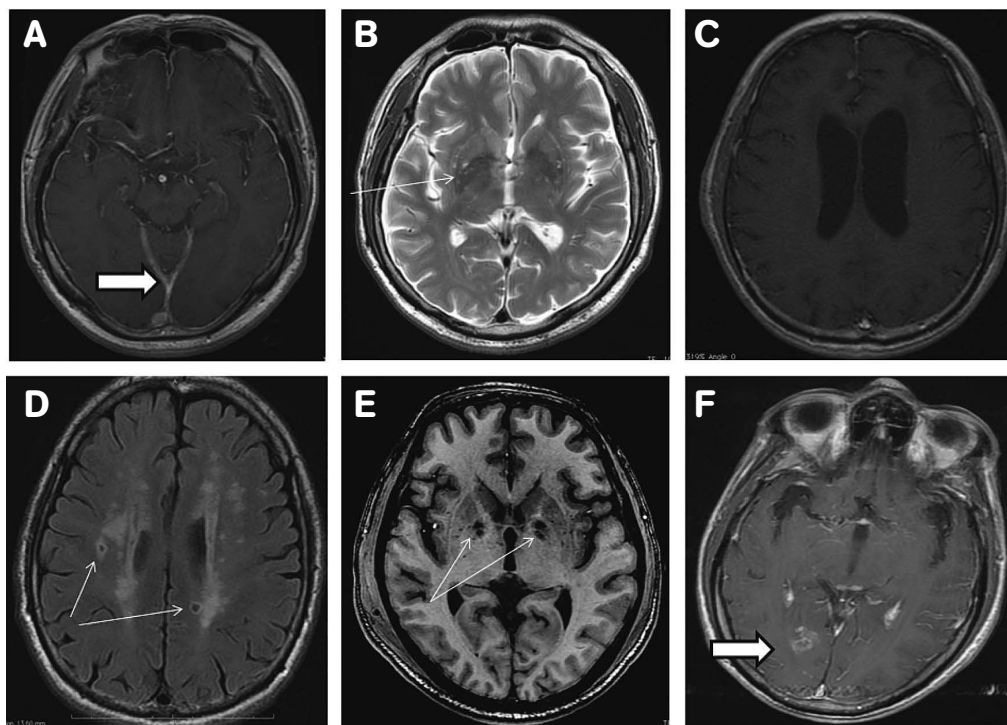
Magnetic resonance imaging (MRI) of Cryptococcal meningitis. (A) MRI axial T1-weighted image with Gadolinium enhancement: patchy meningeal enhancement (clear arrow). (B) MRI axial T2-weighted image: dilated Virchow-Robin spaces (arrow). (C) MRI axial T1-weighted image: hydrocephalus. (D) MRI axial FLAIR-weighted image: multiple isolated or confluent white matter changes and pseudo-cysts (arrow). (E) MRI axial T1-weighted image: Pseudo-cysts (arrow). (F) MRI axial T1-weighted image with Gadolinium enhancement: mass lesion on the right medial occipital region (clear arrow).
